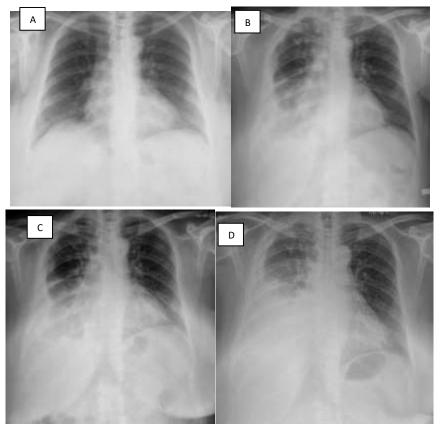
Chest X-ray of the patient (A: September 10<sup>th</sup> 2018, B: November 3<sup>rd</sup> 2021, C: December 27<sup>th</sup> 2021, D: May 11<sup>th</sup> 2022)
